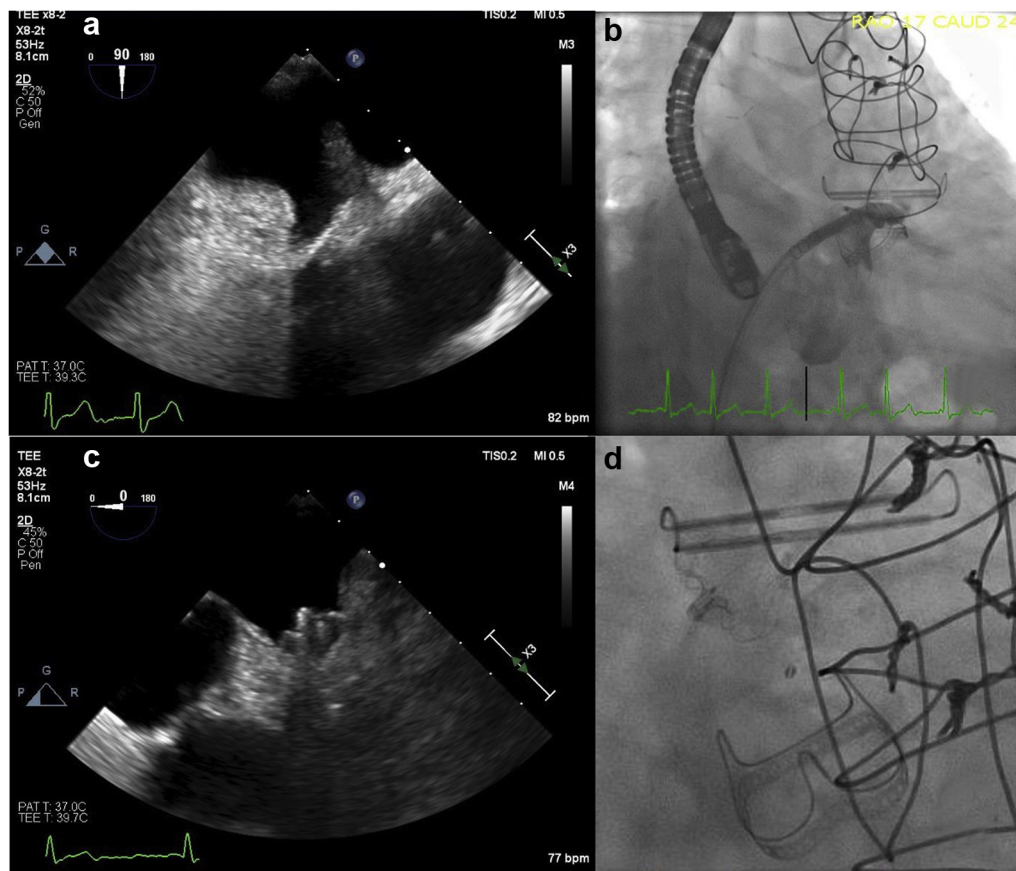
Left atrial appendage AtriClip with residual stump present and post successful Watchman implantation. Residual appendage is visible by echocardiography (a) and angiography (b). Post-Watchman deployment TEE (c) and fluoroscopy (d) showing successful Watchman placement adjacent to the AtriClip device. Abbreviation: TEE, transesophageal echocardiography.
